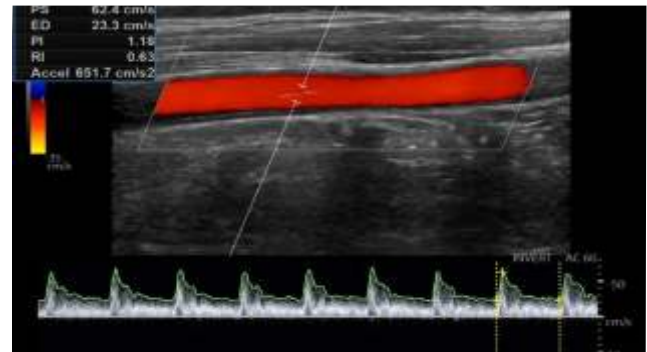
Longitudinal section color Doppler image of normal right CCA showing normal arterial flow with forward diastolic flow at doppler angle of 60 with normal peak systolic & end diastolic value with normal PSV ICA/CCA ratio in 67 years male patient with history of transient ischemic attack with normal NCCT scan of brain.
